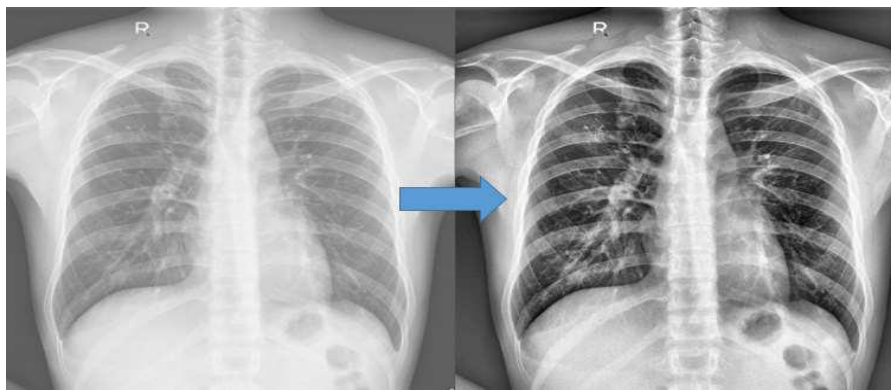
X-Ray Adaptive Histogram Equalization
